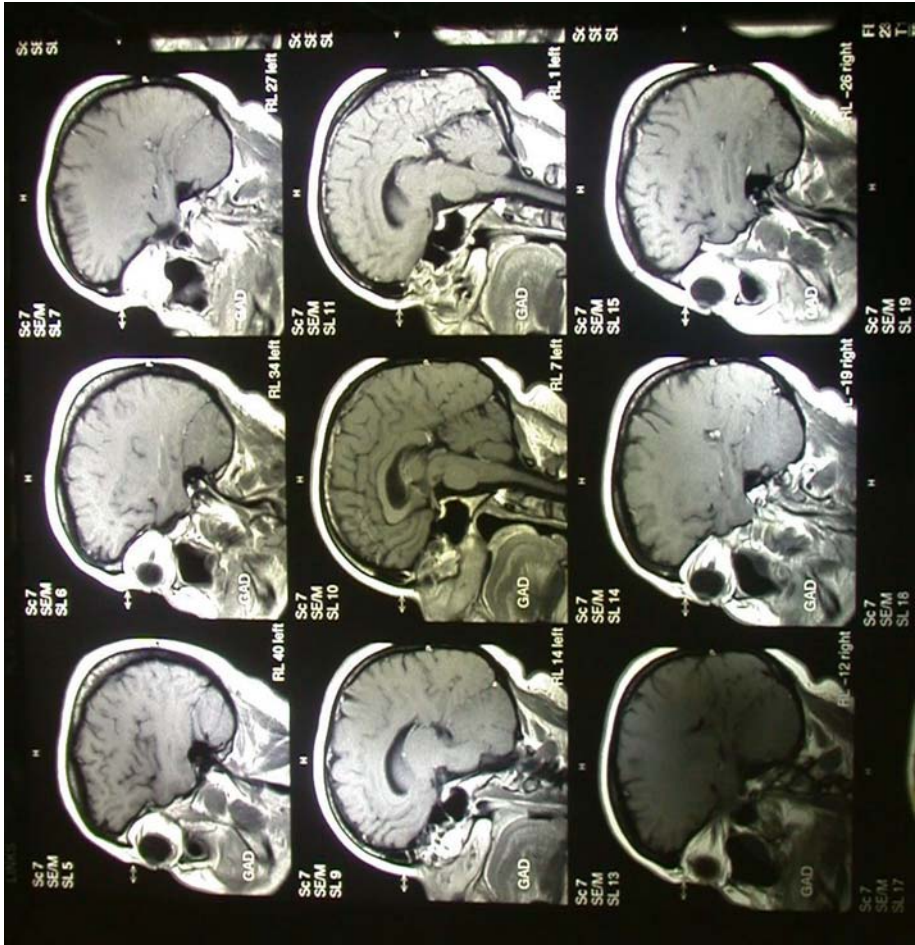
Gadolinium enhanced T1 weighted MRI image of an MS patient after taking the Raphah Regimen plus iron for 30 months. No contrast enhanced hyperintense lesions are visible, indicating that there is no disease activity.
